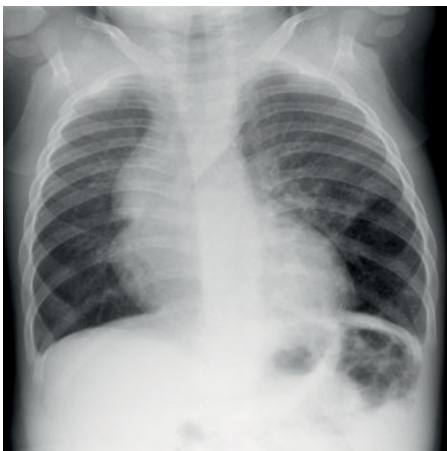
Chest X-ray of a 6-month-old girl with an extralobar bronchopulmonary sequestration in the left lower lobe. The malformation was diagnosed antenatally, and the girl was asymptomatic.
